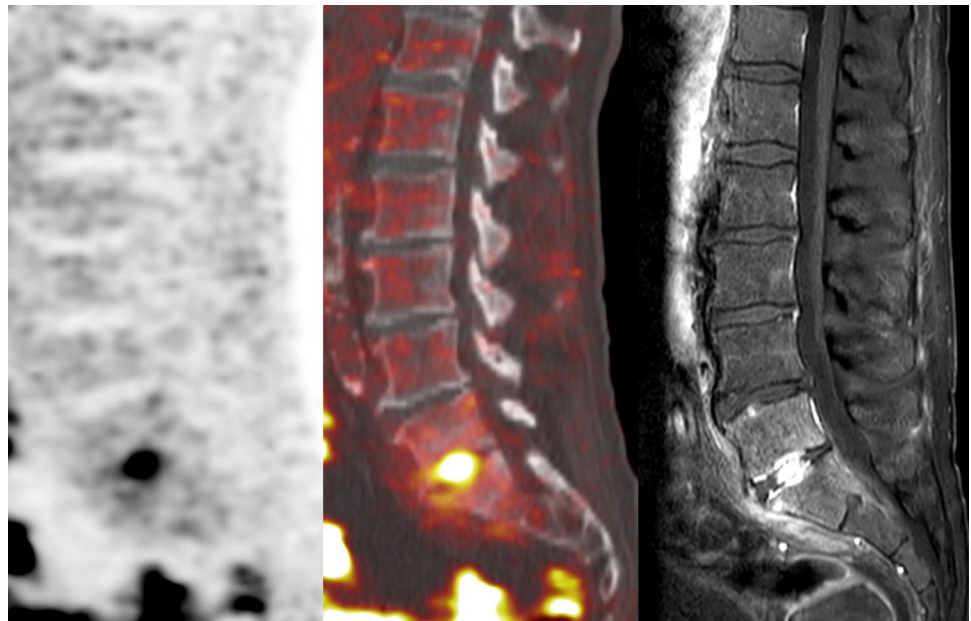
Vertebral osteomyelitis. A 79-year old woman with fever and back pain. Blood cultures were positive for *Proteus mirabilis* and *E. coli*. Portal of entry has not been identified. [^{18}F]FDG PET/CT shows increased uptake in the L4 and L5 endplates, but no increased uptake in the intervertebral disc (sagittal low dose CT, PET and fused PET/
